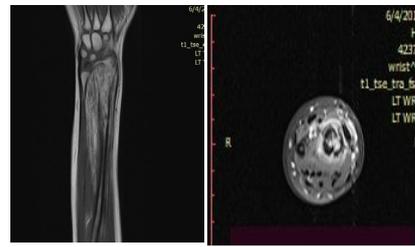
MRI coronal and axial view of left radius ulna
